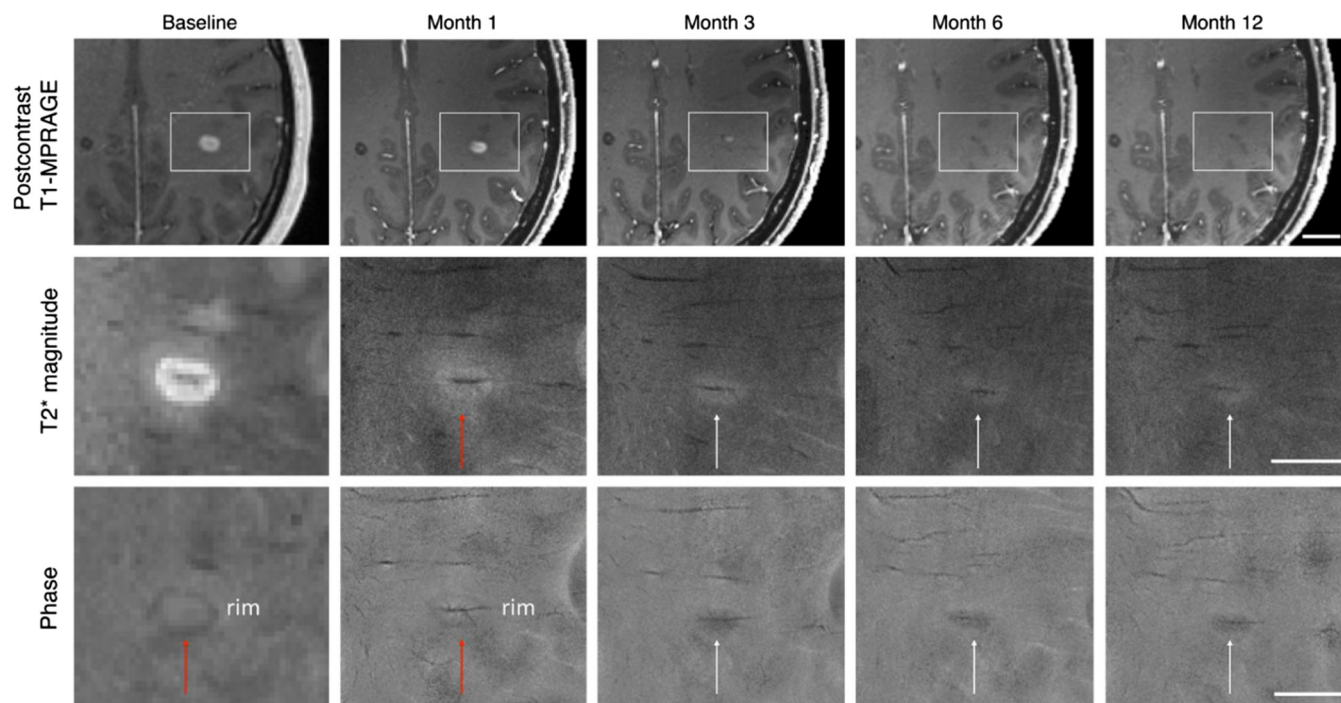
Longitudinal measurements of contrast-enhanced T_1 -weighted and T_2 -weighted images as well as phase images of an MS lesion. In phase images measured at 3 T (column 1, baseline), the central vein in the MS lesion is only very vaguely visible (first column), whereas it can be clearly seen when using 7 T MRI (columns 2–5). The phase rim gradually resolves compared to the baseline and the measurement after one month. Scale bar = 10 mm. Modified from [249].
